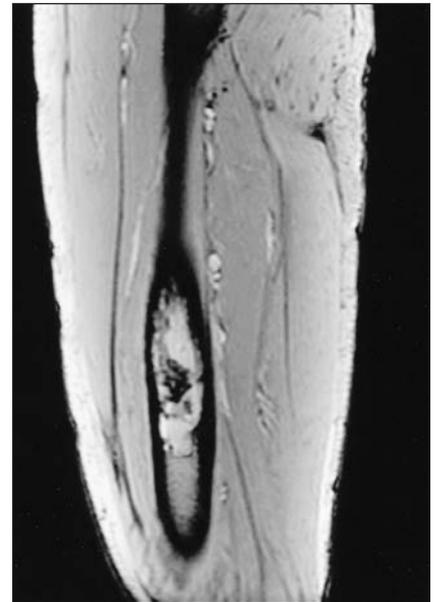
MRI: sagittal gradient echo image.
